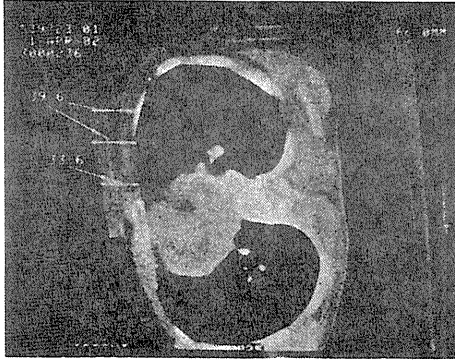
CT view in Fig. 11 to assure treatment depth.
